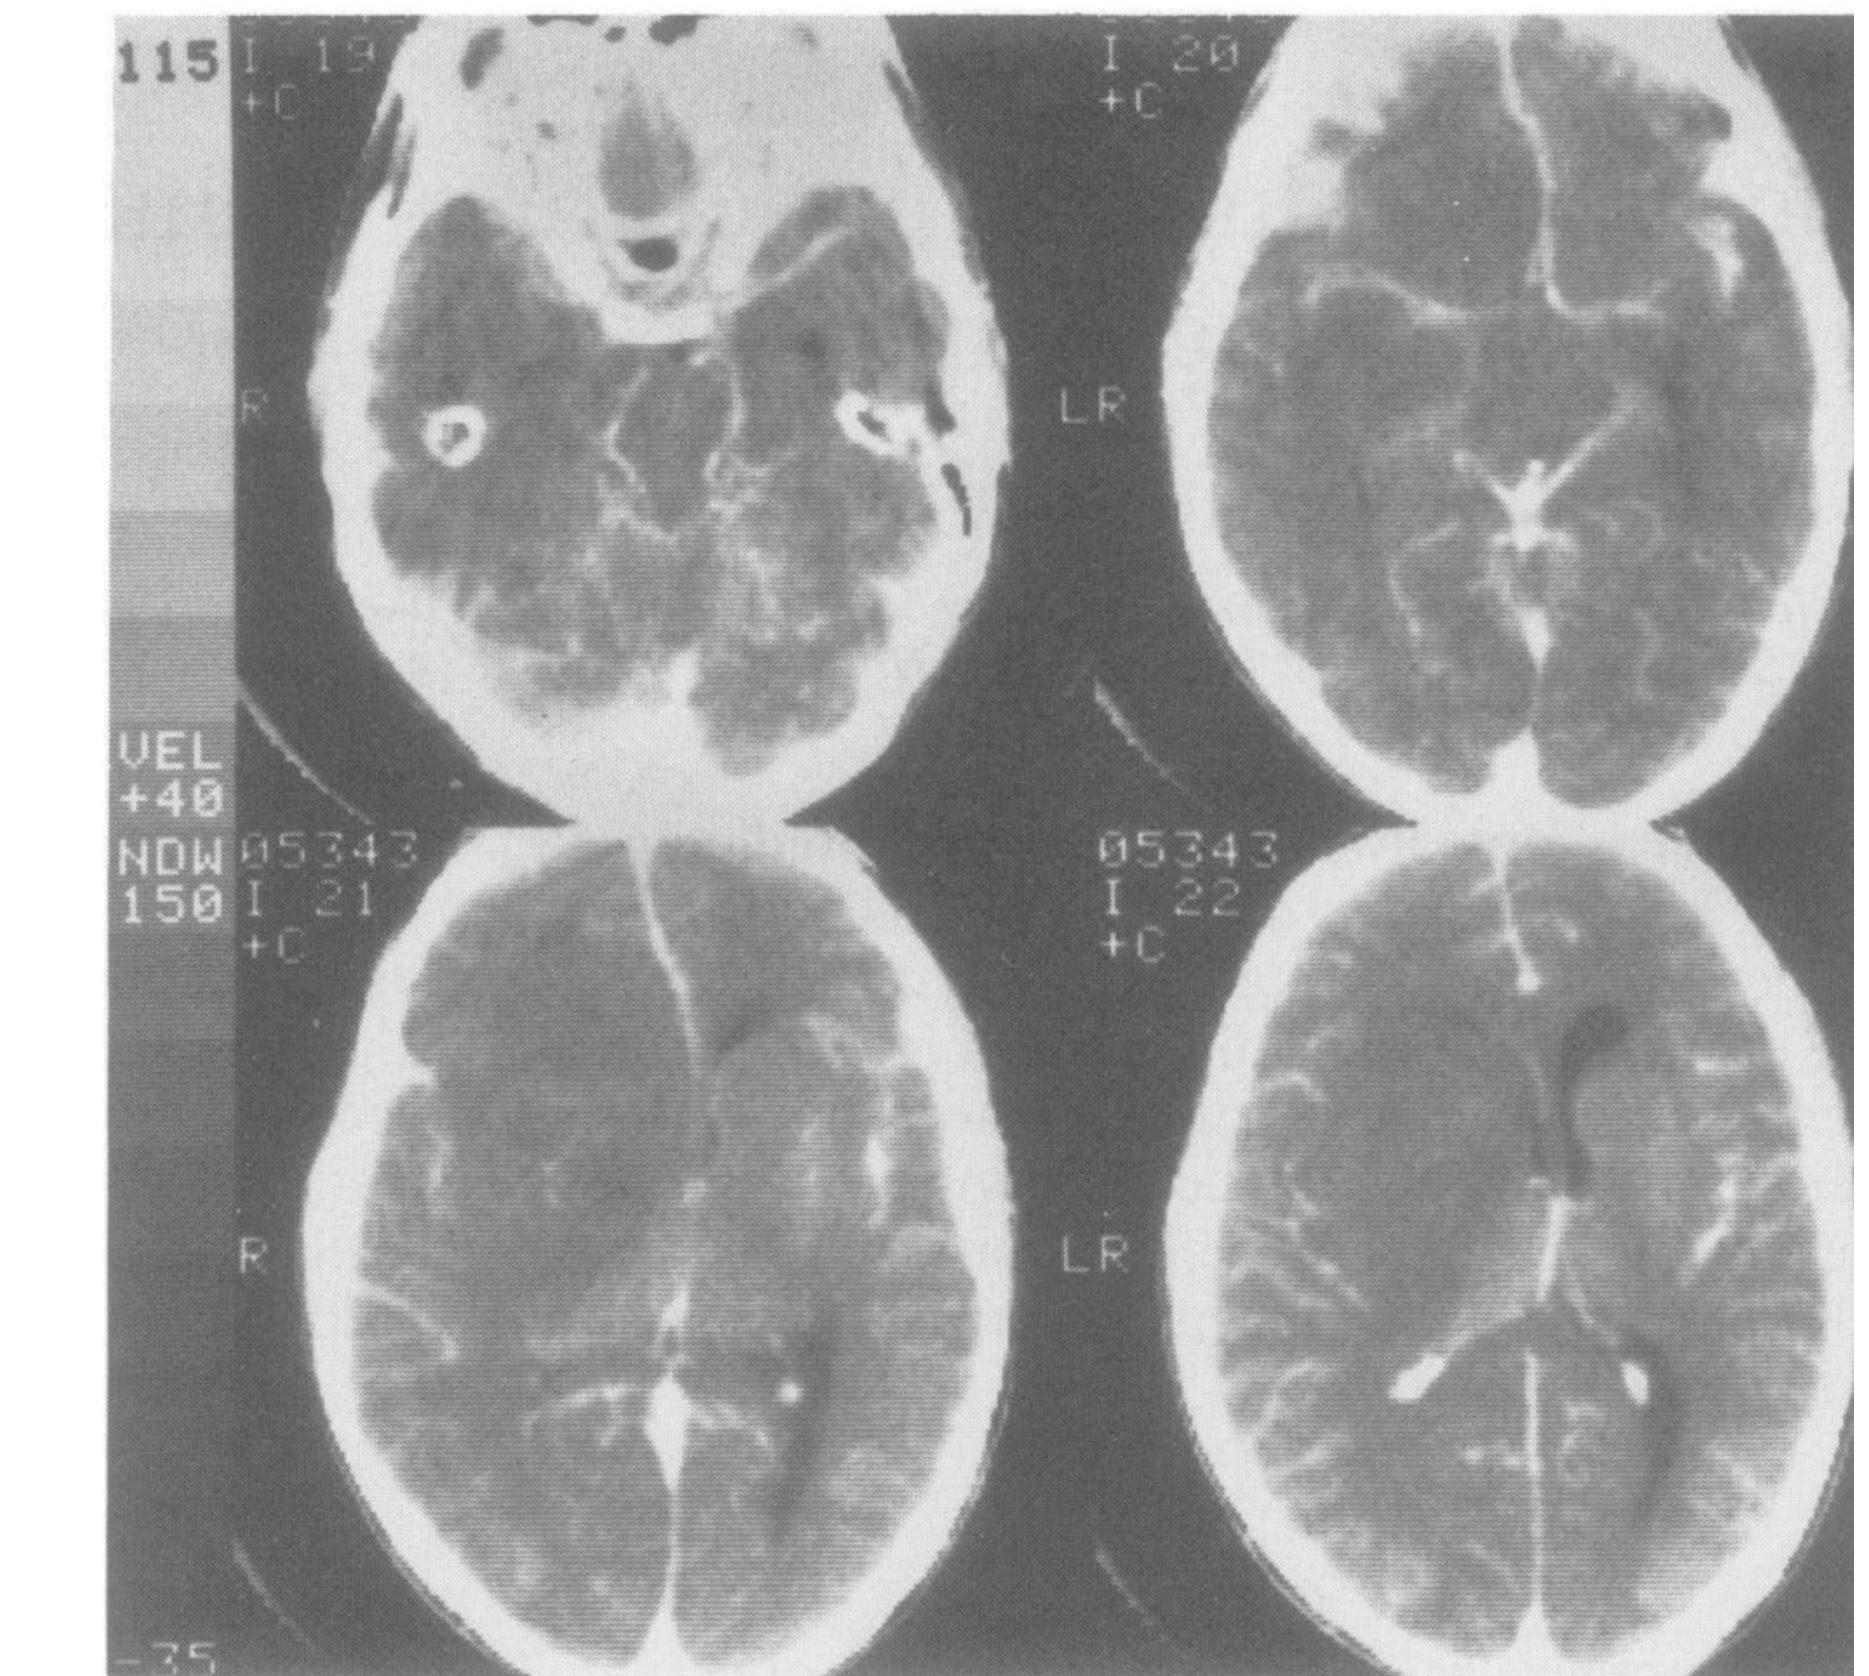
Infused CT scan that demonstrates midline shift and uncal herniation with displacement of the right posterior cerebral artery.
